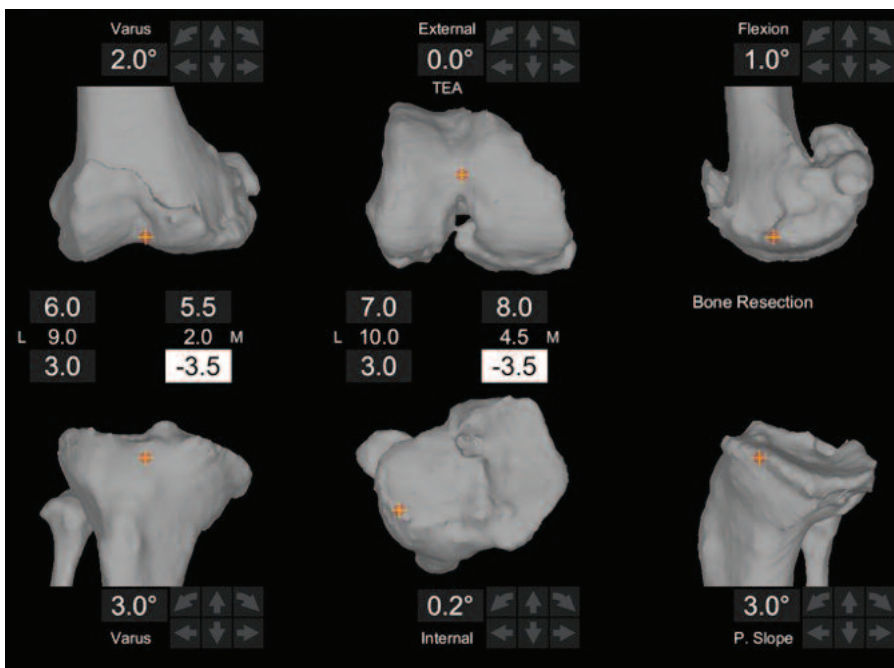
Preoperative CT-based 3D model of the knee showing large postero-femoral and tibial osteophytes.
